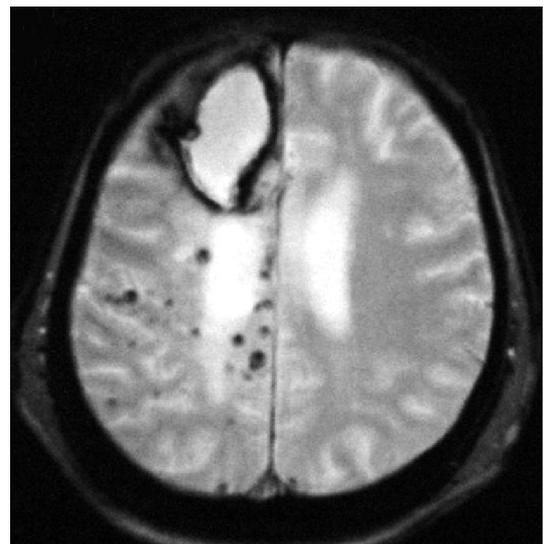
Microbleeds observed in a 63-year-old female with right frontal lobar hemorrhage (MRI T_2^* image).
